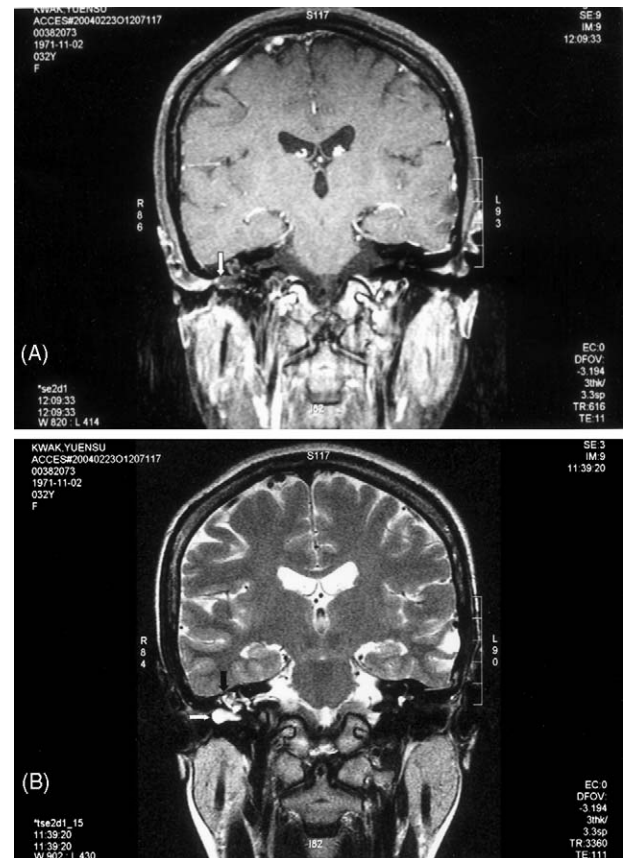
Preoperative temporal bone MRI scan findings. A: T1-weighted coronal MRI shows low signal intensity mass (white arrow) of the right external auditory canal. B: T2-weighted coronal MRI shows about 1.5 cm × 0.6 cm × 1 cm sized high signal intensity mass (white arrow) and the connection (black arrow) between subarachnoid space and cyst of the right external auditory canal.
